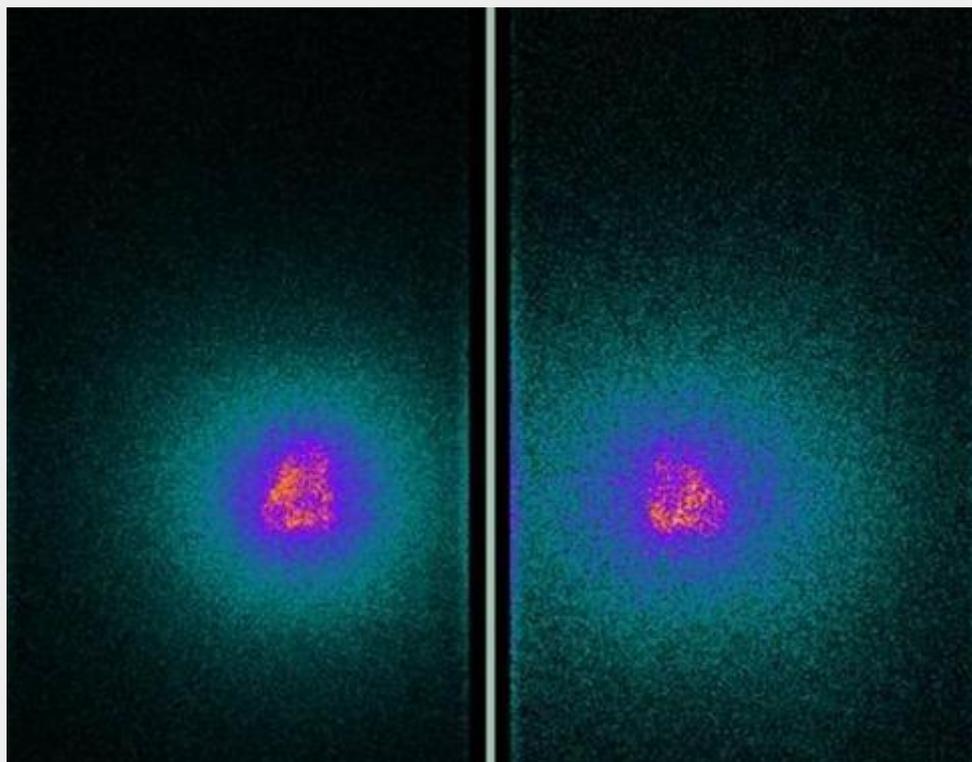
Knee scintigram after injection of Yttrium-90 (anterior and posterior views).
